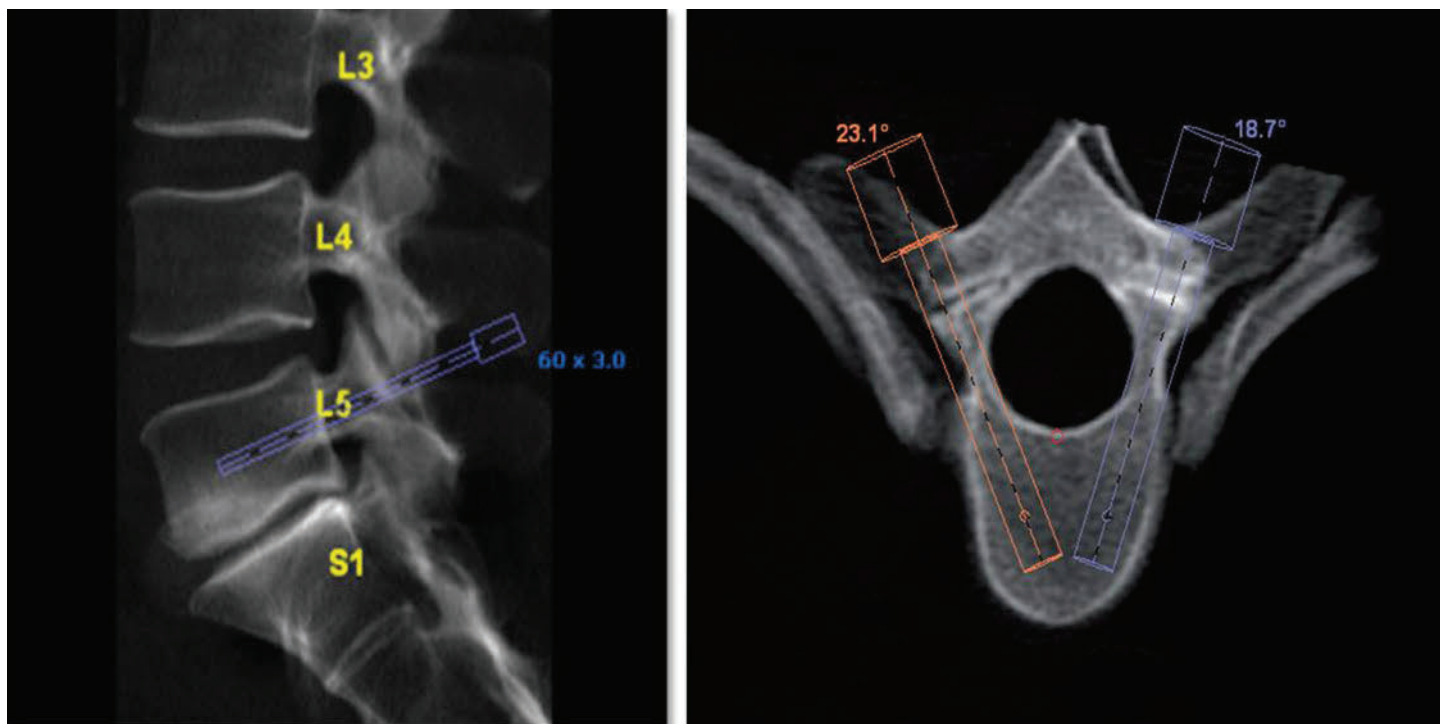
CT scan images of the spine are taken prior to surgery and the exact location of spinal implants is blueprinted with 3D software. The orange and purple lines represent screws that are to be placed into the bones of the spine.
